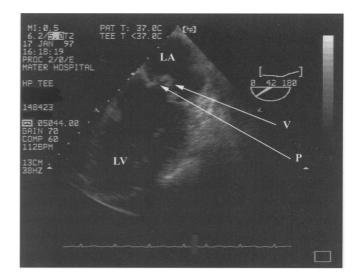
Transoesophageal image showing a large vegetation (V) attached to the anterior leaflet of the mitral valve, prolapsing into the left atrium (LA) at end systole. The relatively echolucent area (P) represents a perforation in the anterior leaflet. LV represents the left ventricle.
